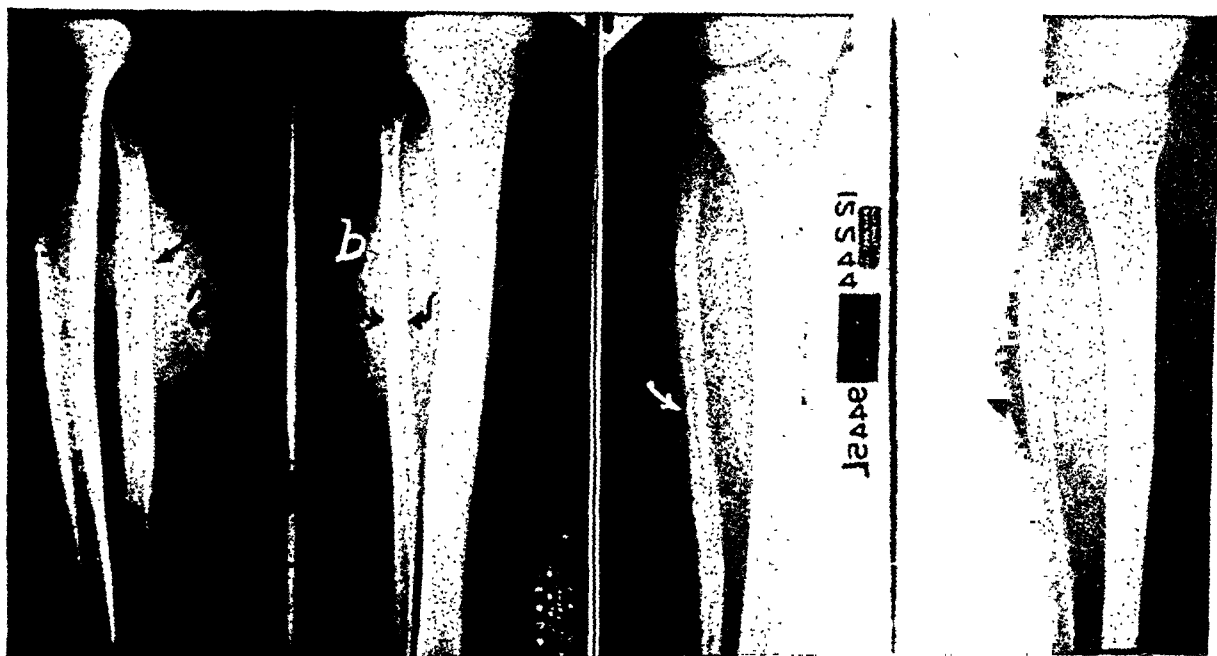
Case IV. Ewing's tumor of fibula. Soft tissue tumor at *a*. The compact bone of the middle third of the fibula is infiltrated and honeycombed by tumor cells. There is a slight constriction of the fibula at *b*. Very slight periosteal reaction is noted in the extreme right film just adjacent to the arrow. This patient, a twenty-five year old Captain in Ordnance, gave a history of "muscle fatigue" of one year. Severe pain did not play an important rôle in this patient's history. Marked improvement followed roentgen therapy which was followed by mid-thigh amputation.
